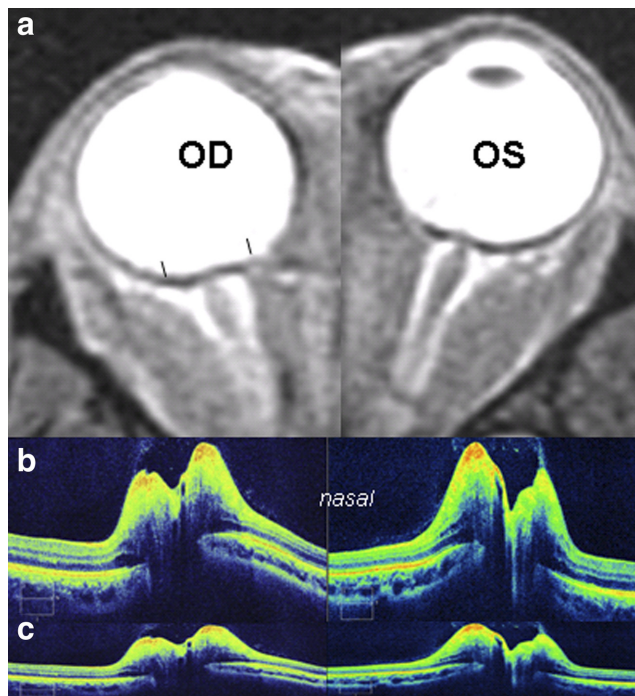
A 39-year-old woman with venous sinus thrombosis, papilledema, and opening pressure of 420 mm. Compare the configuration of the RPE/BM layer on SD-OCT (b, c) to findings on orbital MRI (a). The SD-OCT is displayed in the standard aspect ratio of 3:2 (b) and in the corrected aspect ratio of 9:2 (c). The T2 STIR MRI demonstrates characteristic flattening of the posterior globe with distension of the optic nerve sheath bilaterally. *Black line*: brackets on MRI shows the 9-mm span depicted in the SD-OCT. Note similarities in shape between SD-OCT and MRI.
